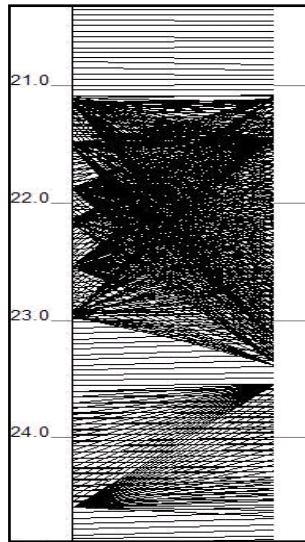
Typical CT Test.
